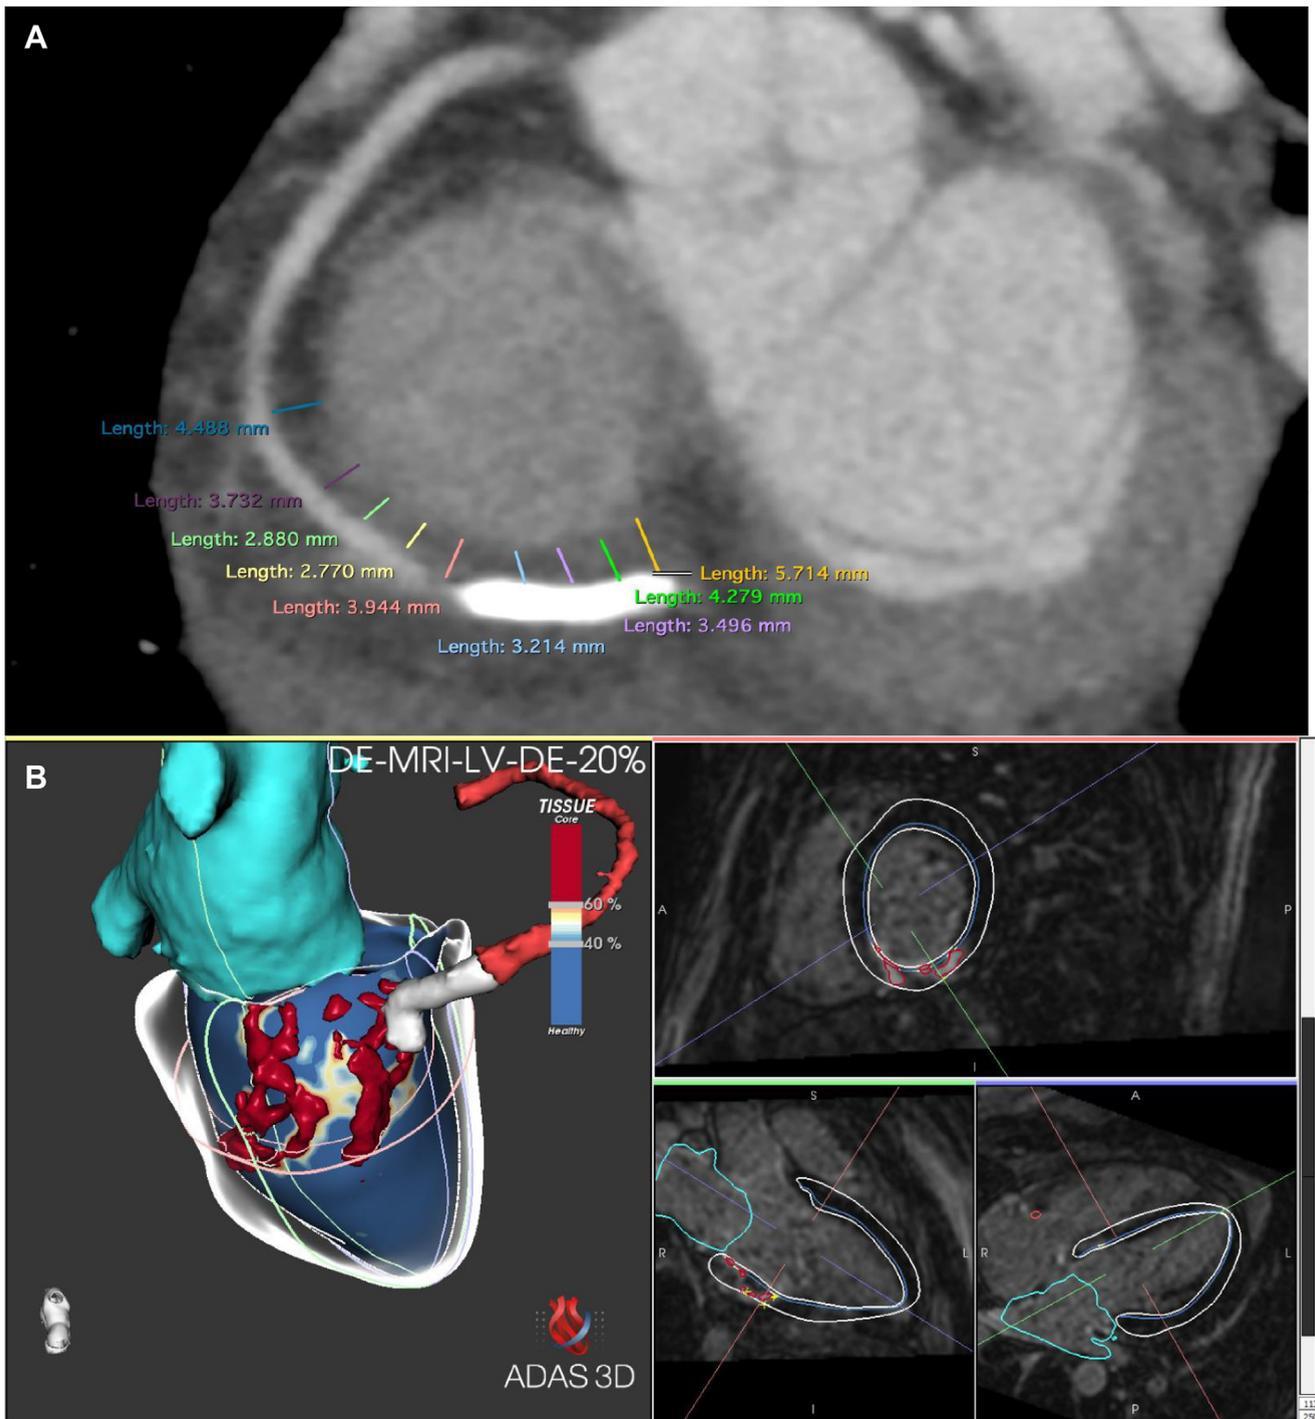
A: Coronary computed tomography angiography showing the relationship between the stent placed and right atrial wall. Note that the distance may be as short as 2.7 mm at the lateral tricuspid annulus (TA) to 5.7 mm at the septal TA. B: Magnetic resonance imaging with 3D reconstruction after 3 days of angioplasty showing left ventricle (LV) inferior basal scar derived from the ST-segment elevation acute myocardial infarction. Note the right coronary artery shown in light red, the stent shown in white, and the scar shown in dark red over the LV surface in dark blue.
